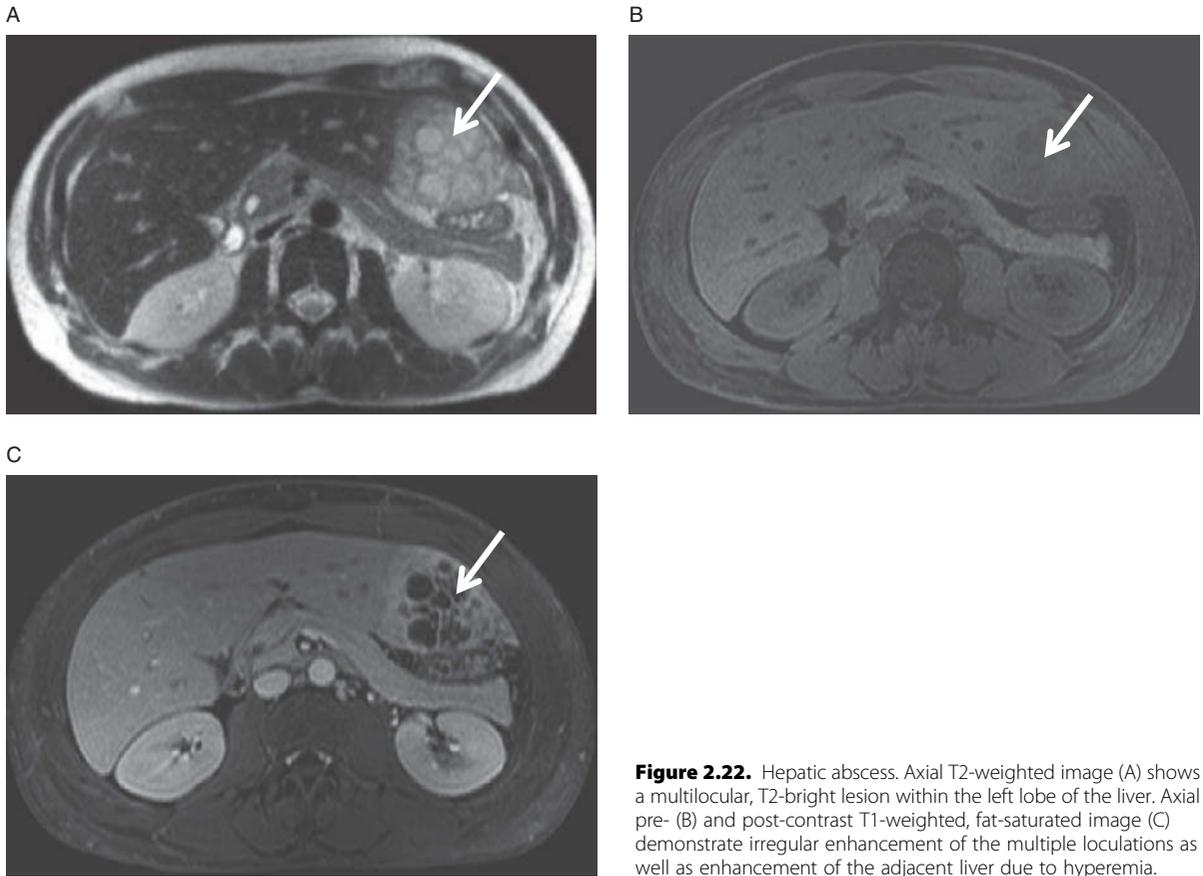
Hepatic abscess. Axial T2-weighted image (A) shows a multilocular, T2-bright lesion within the left lobe of the liver. Axial pre- (B) and post-contrast T1-weighted, fat-saturated image (C) demonstrate irregular enhancement of the multiple loculations as well as enhancement of the adjacent liver due to hyperemia.
